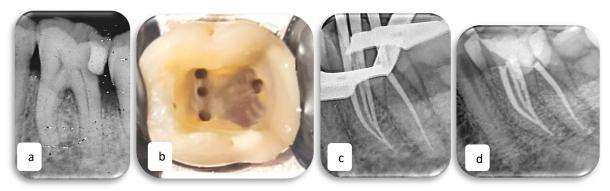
Non-surgical Primary Endodontic Therapy of Mandibular Right First Molar. a) Pre-operative Radiograph; b) Access Cavity Preparation; c) Master Cone Radiograph; d) Post-operative Radiograph.
